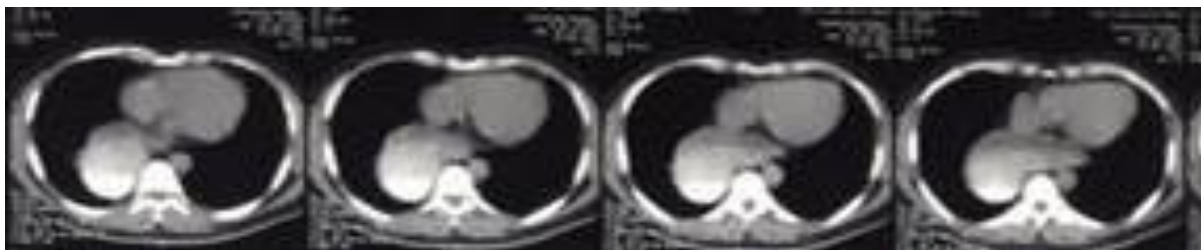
Abdominal CT-Scan: dilatation of the distal esophagus.
